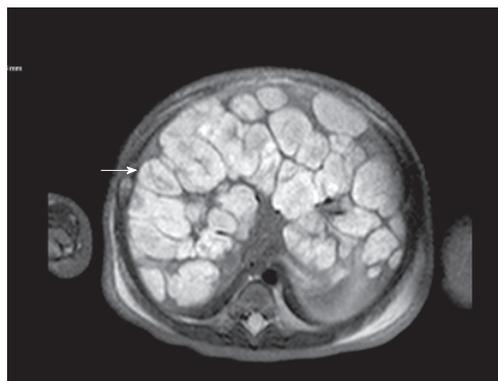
Diffuse infantile hepatic hemangiomas. T2 weighted axial MRI image of a 7-d-old with diffuse hemangiomas. Note the innumerable T2 hyperintense masses throughout the liver with central hypo-intense central regions (arrow). MRI: Magnetic resonance imaging.
